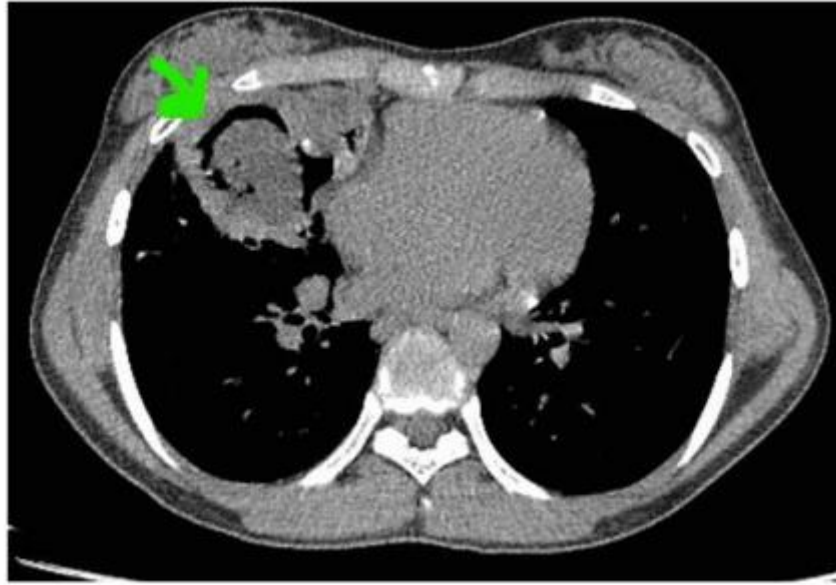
CT scan revealing a thick-walled cavity in the right middle lobe with an air crescent sign (green arrow) and an intracavitary lesion.
